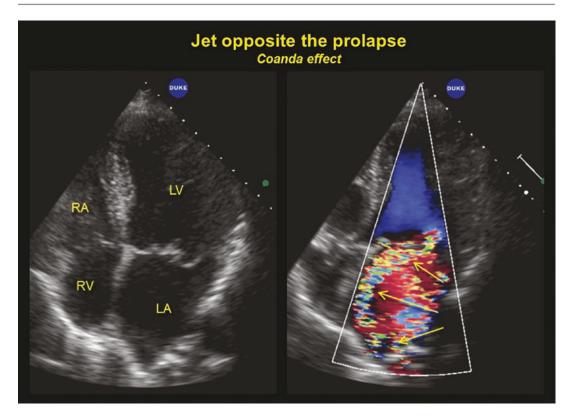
Apical four-chamber view of mitral regurgitation directed against the atrial septum. The jet direction is opposite the prolapsing leaflet
